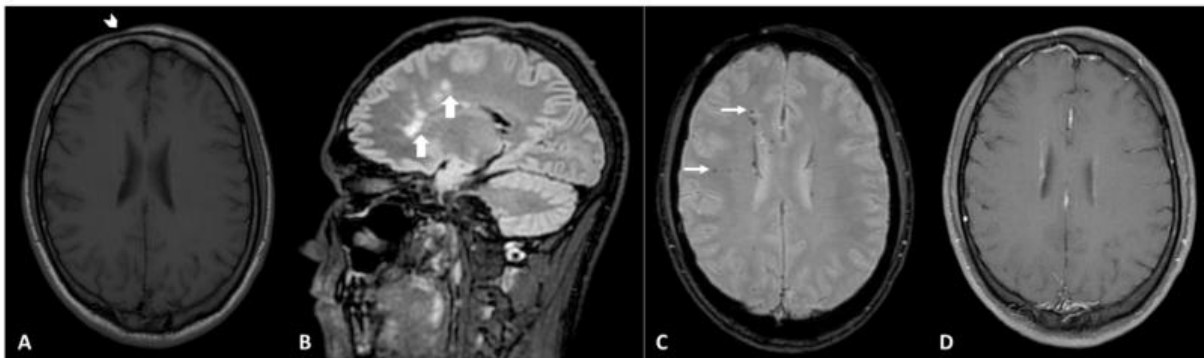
MR images of a 36 year-old man with linear scleroderma. A, Axial T1-weighted MR image demonstrates right atrophy of the skin and subcutaneous fat (arrow head). B, Sagittal FLAIR image demonstrates abnormal hyperintensity of the white matter in the right frontal corona radiata (thick arrow). C, Axial susceptibility-weighted image demonstrates innumerable punctate foci of susceptibility throughout the right cerebral hemisphere (thin arrows). D, Axial enhanced T1-weighted MR image does not demonstrate anomalous enhancement of skin and brain.
